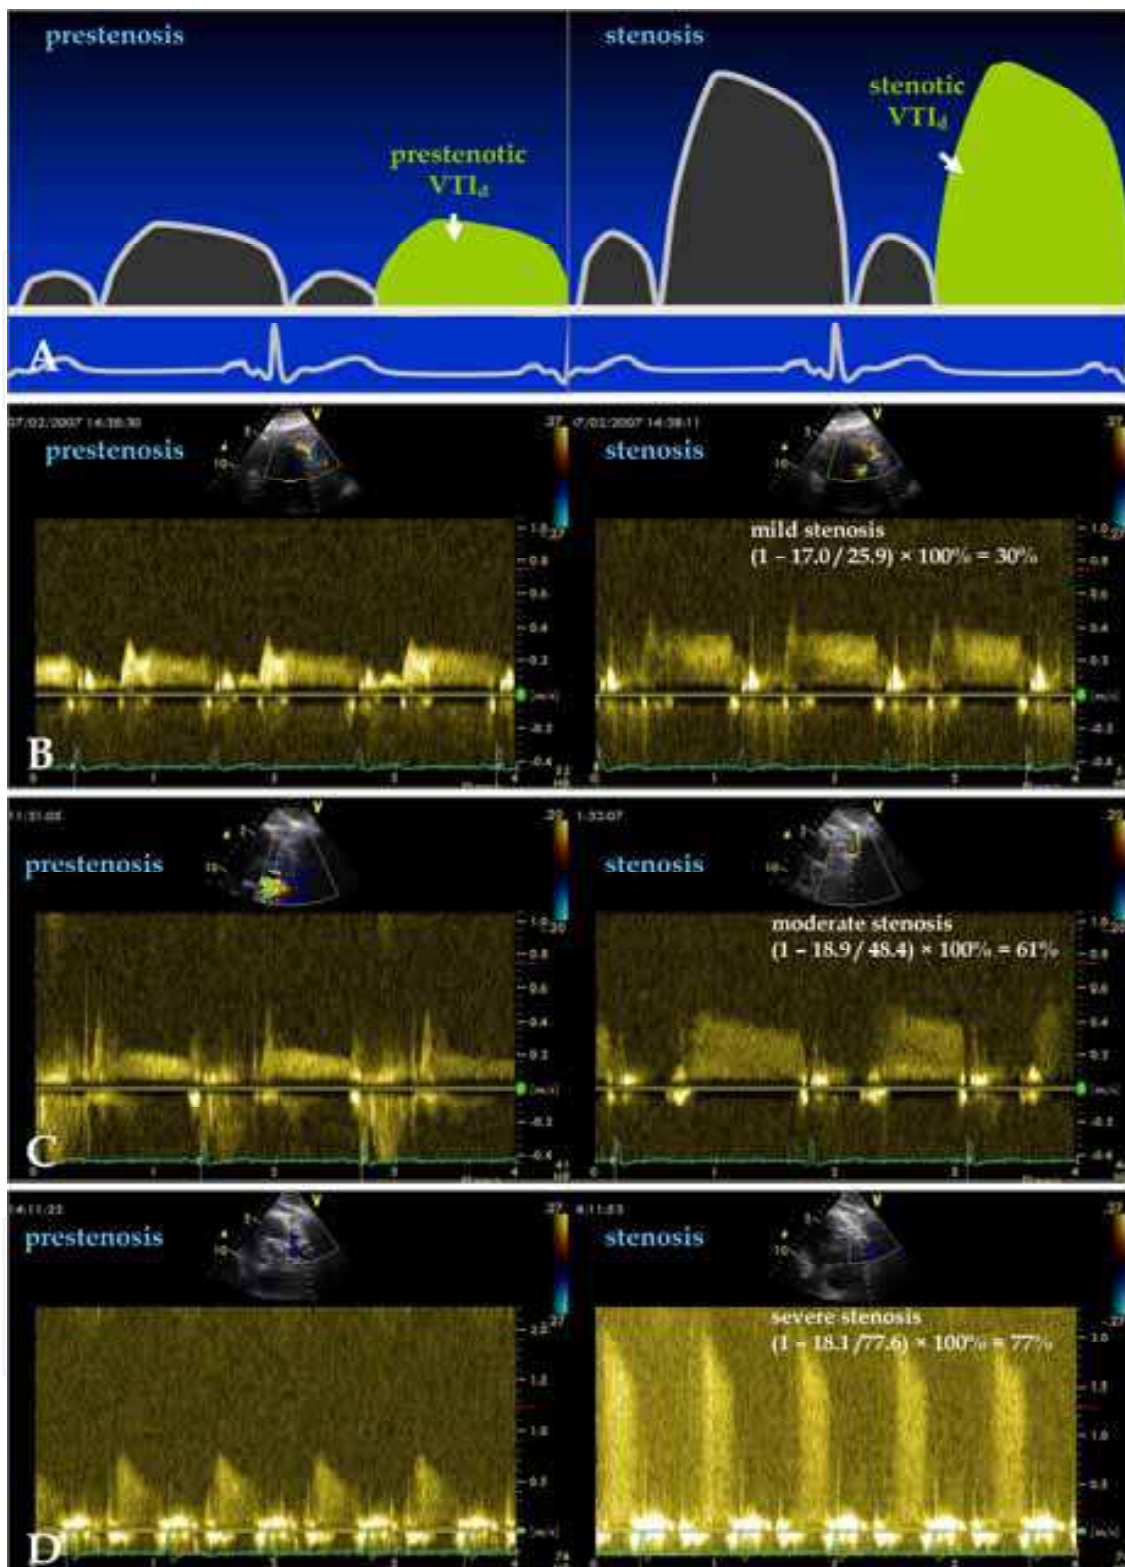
Calculation of stenosis % area of proximal LAD according a modified continuity equation by TTE. A - scheme of calculation by TTE; B - example of Doppler flow patterns in patient with 35% stenosis according to coronary angiography data; C - Doppler flow patterns in patient with 60% stenosis; D - Doppler flow patterns in patient with 80% stenosis; VTI<sub>d</sub> - diastolic time velocity integral
